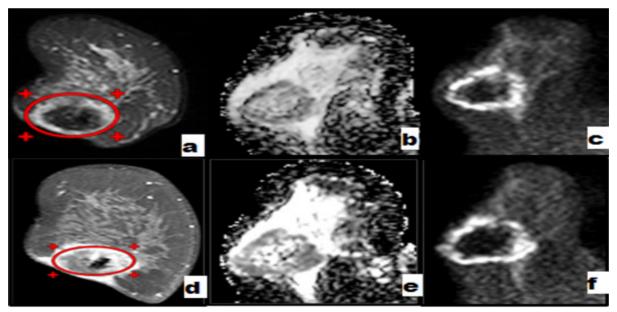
Pre-neoadjuvant MRI findings (a,b and c images) were as follows: a: Post contrast fat suppression 3D Volumetric MIP showing intense marginally intensely enhancing irregular outer surface mass lesion with non-significantly enhancing central degeneration. b: ADC revealed dark "low" signal thick peripheral margin of the mass lesion, denoting restricted diffusion with ADC value (10^{-3} mm² /s =0.99). .c: DWIs images shows a well-defined lesion with hyperintense "bright" peripheral margin. The average estimated volume was about 65-70 cm³. Post NAST therapy MRI study (d,e and f images) were as follows:d: post contrast 3D Volumetric MIP revealed still noted marginally enhancing mass lesion showing subtle volume reduction with an average estimated volume measured about 60-65 cm³ denoting a non-respondent to the treatment. e: ADC and f: DWIs images: revealed bright peripheral margin in DWIs "f image" and low signal in ADC map "e image" denoting also still noted diffusion restriction with ADC value (10^{-3} mm² /s =1.1). No appreciable necrotic component either at pre or post NAST therapy.
